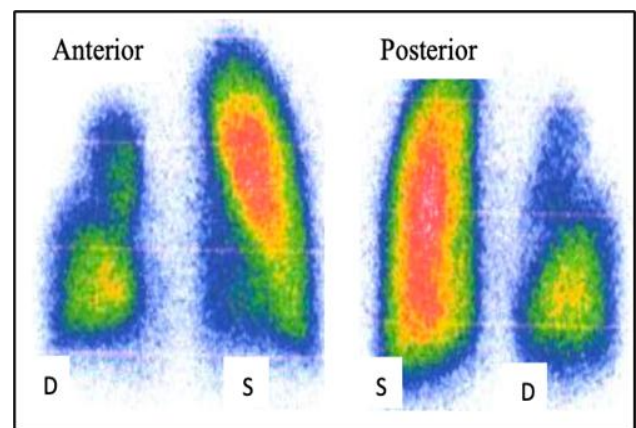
Lung scintigraphy (perfusion) with Tc99m MAA: the anterior and posterior scintigraphic image showed: the right lung is reduced in size (postoperative status), blurred contours in the upper lobe, uneven distribution of the radiopharmaceutical substances, diffuse increase of the lung blood perfusion, especially in the upper segments; and blood perfusion changes in the left lung are not found.
